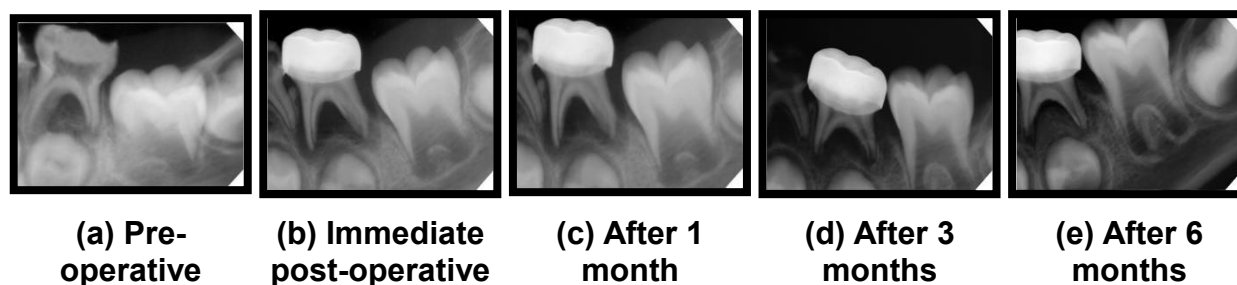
Radiographs show 3Mixed-MP treatment at different follow up periods (a,b,c, d& e)
